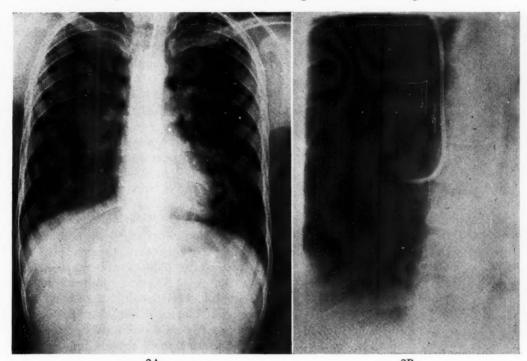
Case VIII. A, roentgenogram; pulmonary stenosis with transposed pulmonary veins; B, catheter entering a right pulmonary vein from the right atrium.
